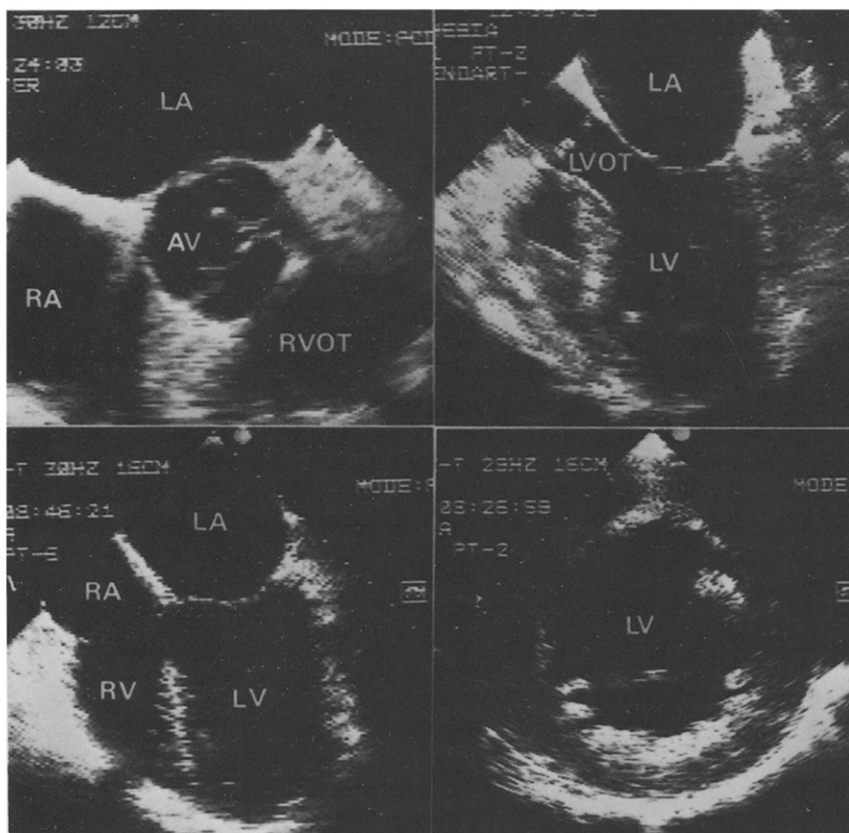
Transesophageal images from 5 MHz 64-element phased-array system. *Upper left*, Short-axis view through base showing three cusps of aortic valve (AV) in partly opening systolic position. *Upper right*, Long-axis view of left ventricle (LV) and left ventricular outflow tract (LVOT). *Lower left*, Four-chamber view images of left and right atria (LA, RA) separated by interatrial septum and left and right ventricles (LV, RV) separated by interventricular septum. Orientation of this four-chamber view defines orientation of other views. *Lower right*, Short-axis view of left ventricle at papillary muscle tips. Right ventricle is just out of the sector to the viewer's left. Inferior wall is at top of image, septum to the left, free anterior wall at bottom and posteroinferior wall to the right.
